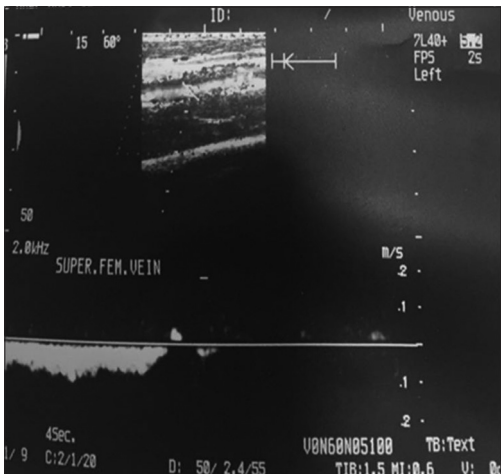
Color Doppler ultrasonography showing normal lower limb venous system
